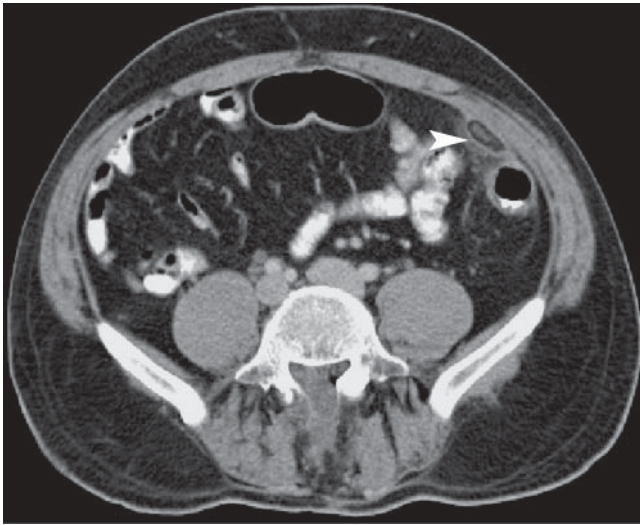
Case 1. Contrast-enhanced computed tomography of the abdomen showing a well-defined fat-containing structure with central hyperdensity (*arrowhead*). The lesion is seen arising from the serosal surface of the descending colon adherent to the visceral peritoneum. There is also mesenteric stranding
